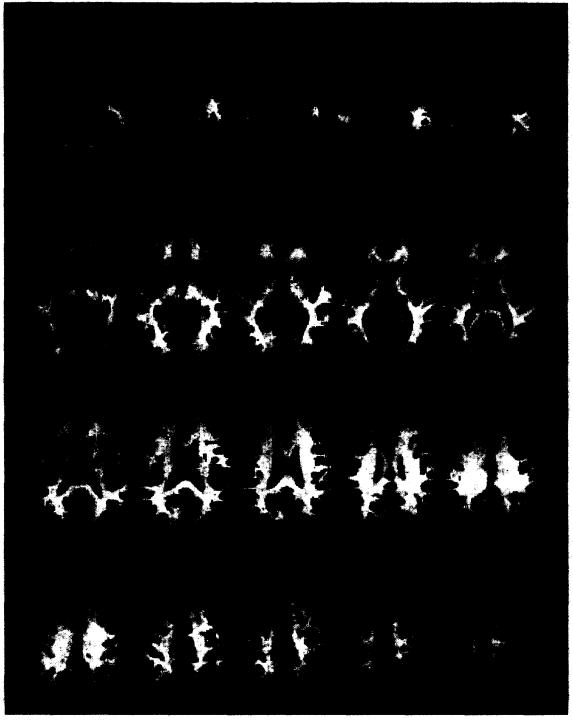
Statistical parametric map showing pixel-based comparison of cerebral glucose metabolism for n = 16 adolescents with childhood onset schizophrenia and n = 26 healthy adolescents. For each pixel, t-values have been converted to z scores linked to a color scale where orange and blue indicate pixels for which schizophrenic subjects had, respectively, significantly higher and lower metabolic rate at $P \le 0.005$. SPM data have been projected onto a standardized magnetic resonance image of a brain sliced transversely, parallel to the intercommissural (AC-PC) line, at levels corresponding to the atlas of Talairach and Tournoux (1988).
